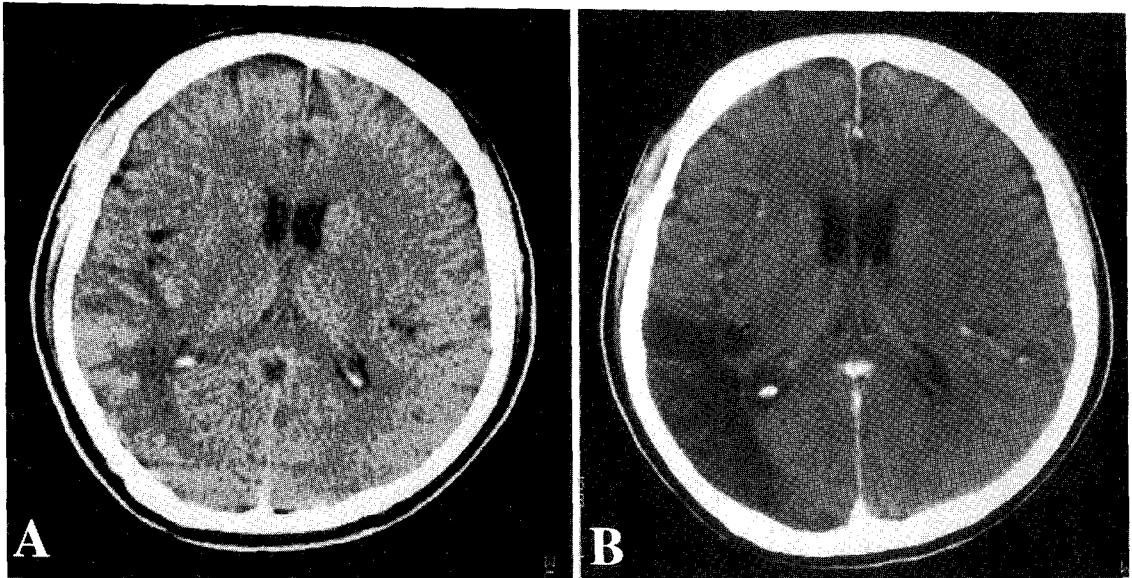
Axial non-contrast CT scans performed 7 days before (A) and one month after (B) the bone scintigraphy demonstrate acute hemorrhagic and chronic cerebral infarction on the right temporo-parieto-occipital region.
